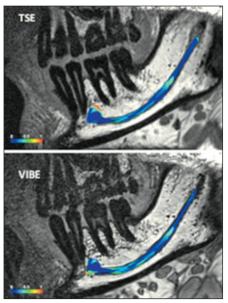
MRI of the mandibular nerve canal, the newer measurement protocol is depicted on top, the older on the bottom. Despite two different measurement and segmentation methods the inferior alveolar nerve is depicted clearly.
